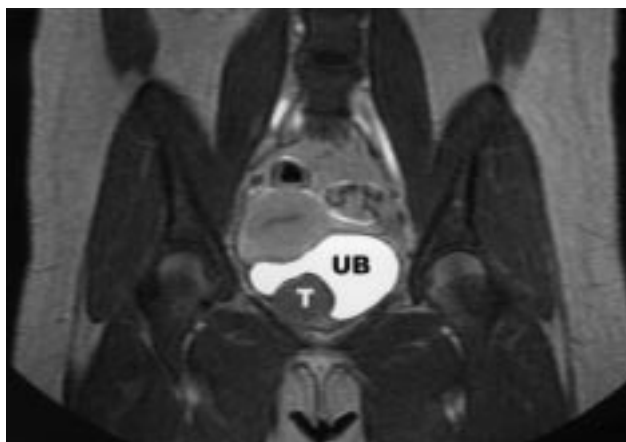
Magnetic resonance imaging demonstrates identical tumor (T) location in the urinary bladder (UB) with enhancement (T1-weighted, coronal view).
